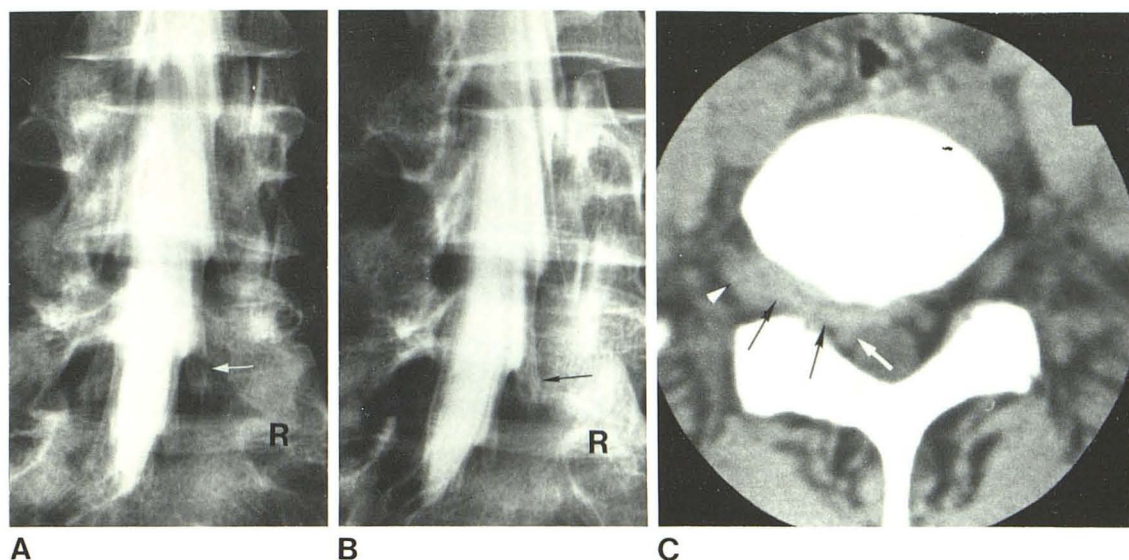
Lateral L5-S1 herniated disk on myelography and CT. A and B, Oblique spot films from metrizamide myelogram. Satisfactory opacification of right S1 root sheath (arrows). No deformity of dural sac or displacement of root sheath. C, Axial CT image at L5-S1 level. Extensive lateral disk herniation (black arrows) displaces fat within intervertebral foramen and anterior epidural space. Right L5 nerve (arrowhead) displaced laterally and right S1 root sheath (white arrow) displaced posteriorly. Lack of dural sac deformity despite extensive disk herniation. (This case, courtesy of O. Petter Eldevik, Ulleval Hospital, Oslo, Norway, was included because few of our patients with herniated disks were studied with both myelography and CT.)
